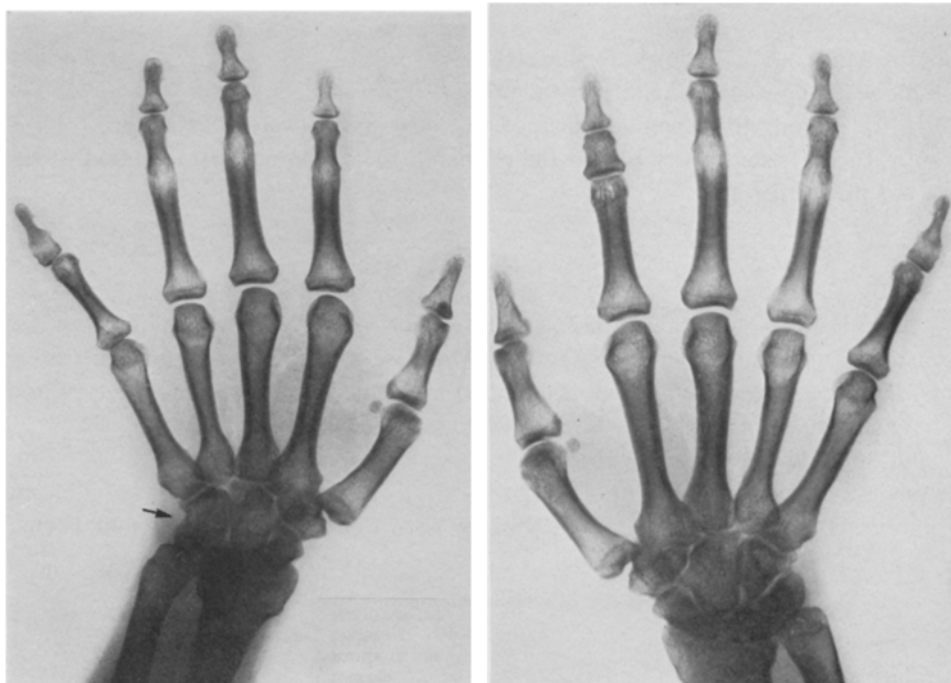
Roentgenogram of the hands of the mother of kindred 1. Synostosis between the basal and middle phalanges of bilateral index, middle and ring fingers, that between the middle and terminal phalanges of bilateral little fingers, and that between the left os hamatum and os triquetrum (arrow) are observed.
